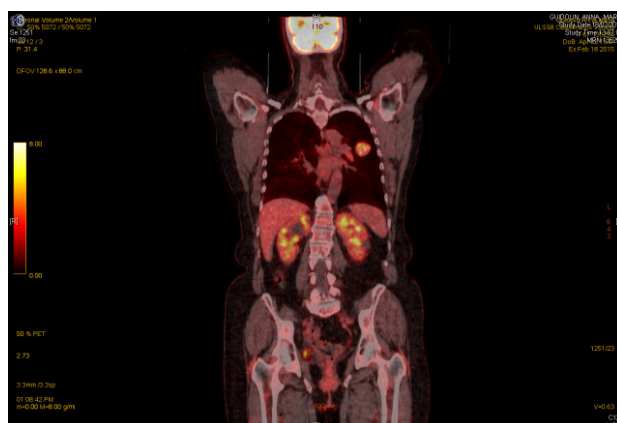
18F-FDG-PET showing a mild (SUVmax =5.6) FDG activity within the lesion.
